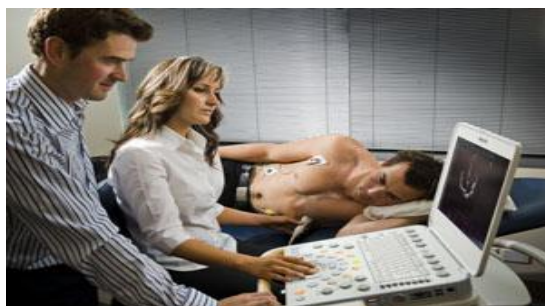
Participant undergoing cardiac ultrasound
